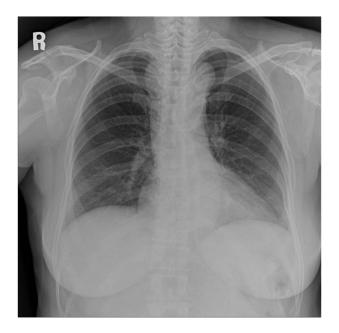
Chest radiography. Wide mediastinum and bilateral aortic knobs are shown.
